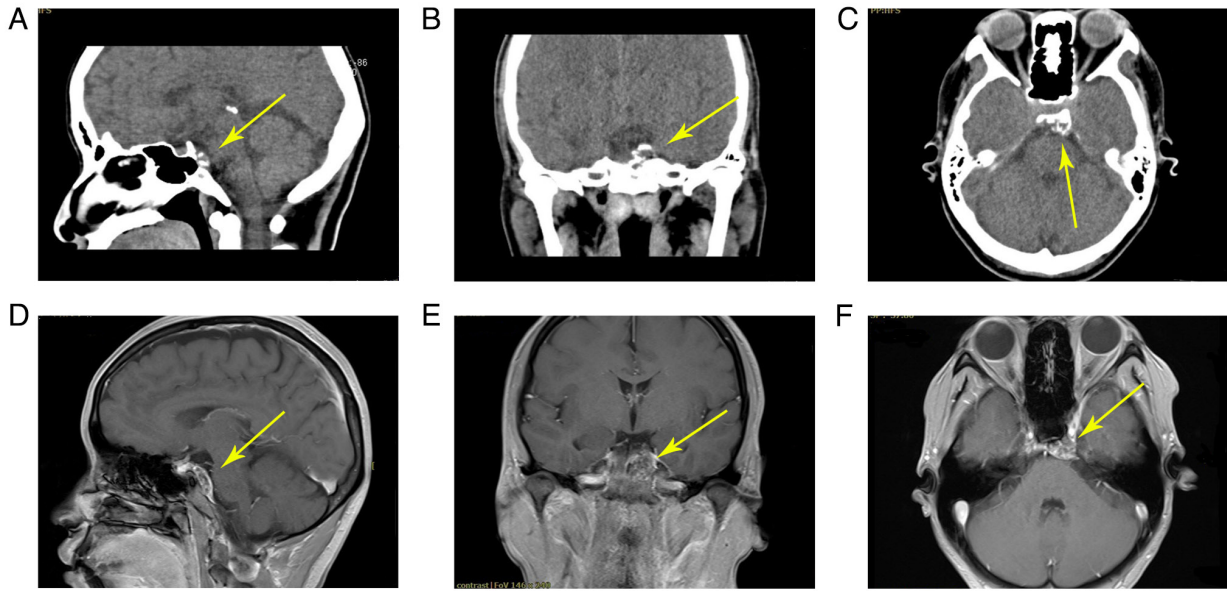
Preoperative CT and MRI images. (A) Sagittal image of the preoperative CT. (B) Coronal image of the postoperative CT. (C) Axial image of the preoperative CT. The preoperative CT showed calcification with a clear margin and enhancement on the clivus. (D) Sagittal image of the preoperative MRI. (E) Coronal image of the postoperative MRI. (F) Axial image of the preoperative MRI. The MRI revealed a mass on the left side of the midline. Yellow arrows indicate the location of the lesion. CT, computed tomography; MRI, magnetic resonance imaging.
